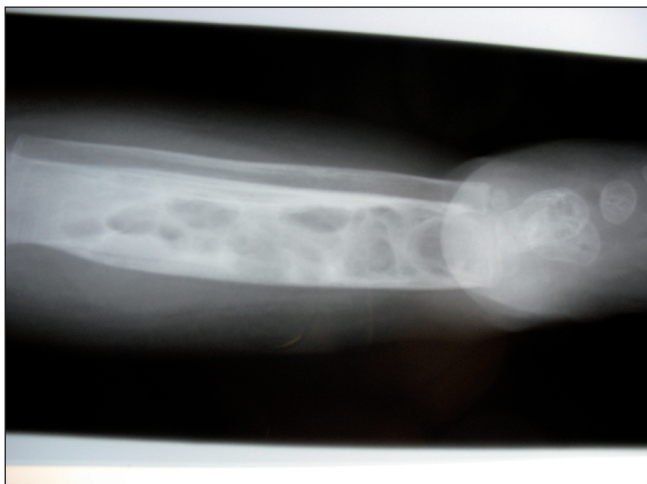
X-ray of tibia: multiple lytic lesions.
